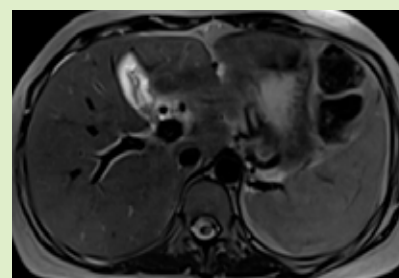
MRI of the abdomen revealing hepatomegaly with edema of gall bladder wall
